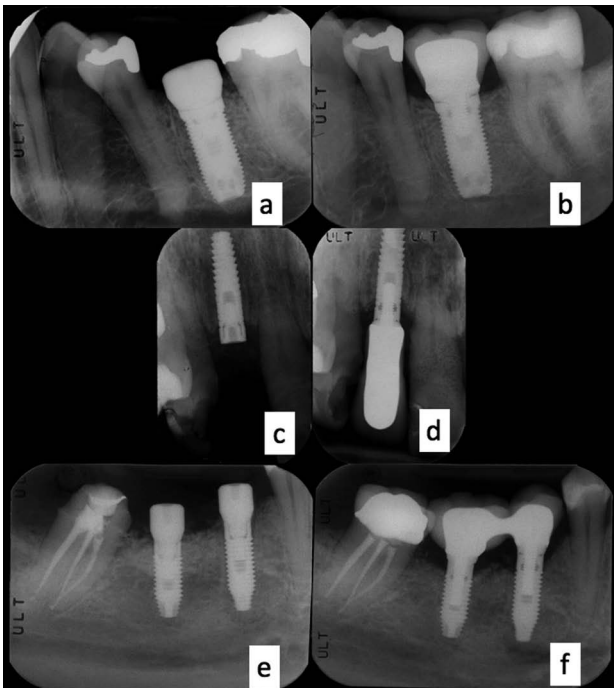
Intra-oral x-rays of three clinical cases: (a, c, e): immediately after the implant placement; (b, d, f): at the end of follow up, after prosthetic finalization.
